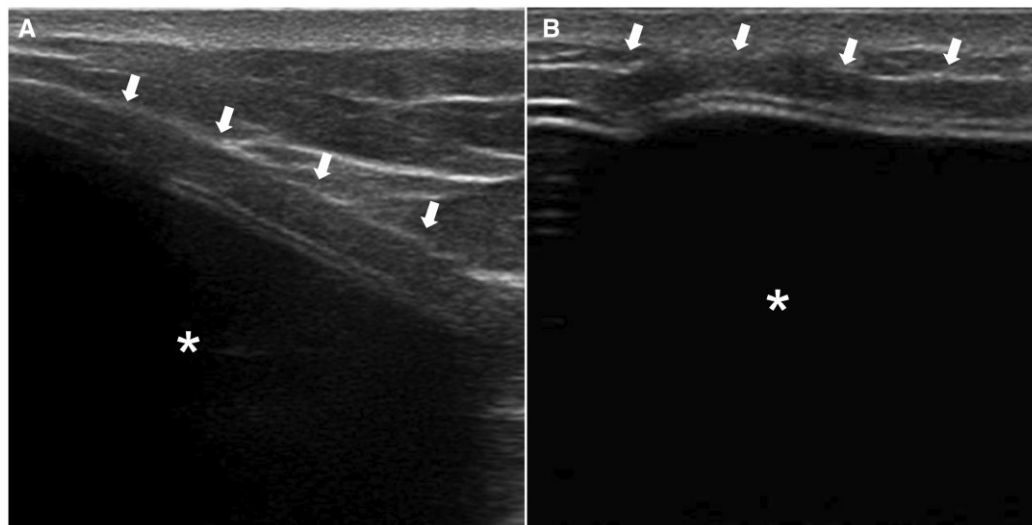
Acellular dermal matrix (ADM) ultrasound features. At ultrasound, ADM may be visible as a hypoechoic periprosthetic layer (white arrows) along the edge of the prosthesis (white asterisk) in the outer-lower (A) and inner (B) quadrants.
